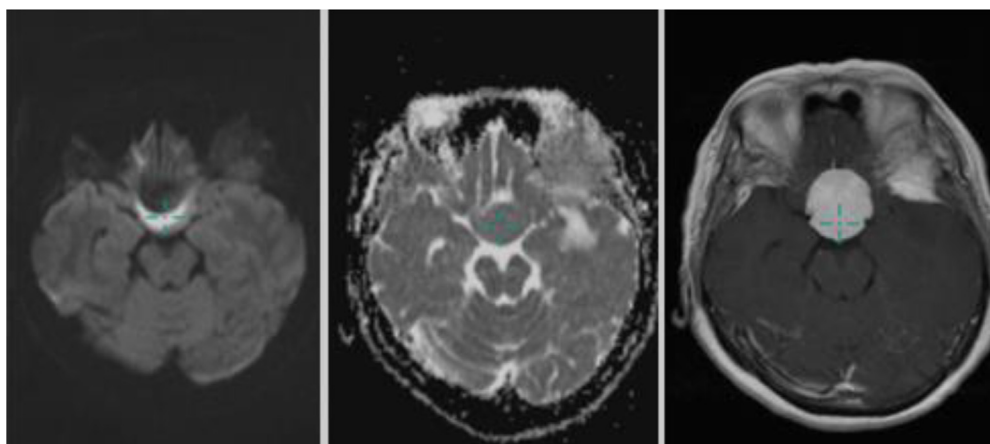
(A) The DWI ADC examination conducted in the solid mass sellar region revealed restricted diffusion. (B) The DWI ADC examination revealed no restricted diffusion in the solid mass left temporal lobe concavity region (A) and left frontal lobe concavity region (B).
